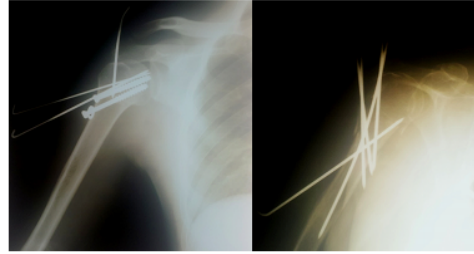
Direct radiographic images of athlete patients on whom we applied proximal humeral fracture surgical osteosynthesis
